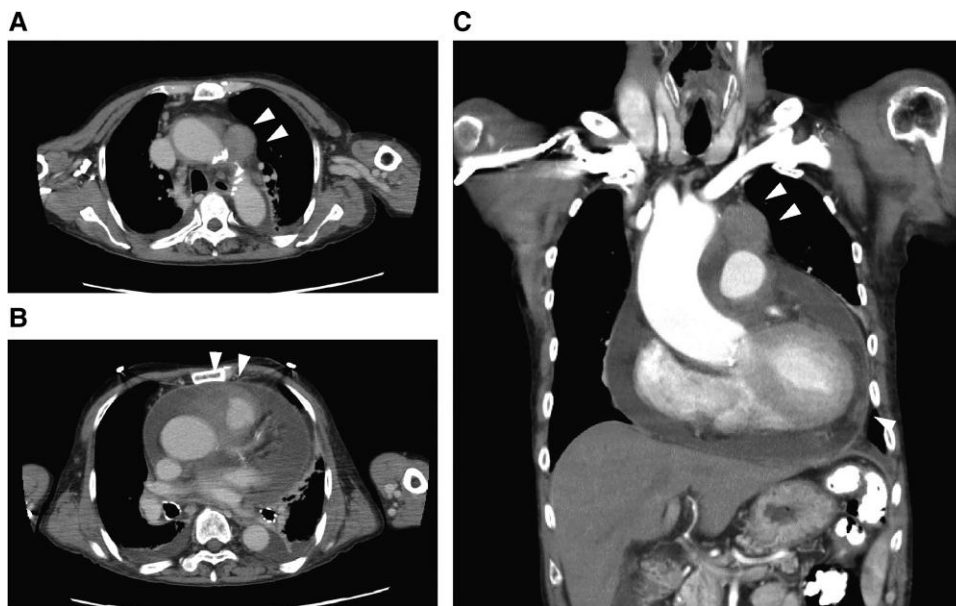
Contrast-enhanced computed tomography. The transverse (A, B) and coronal (C) sections. A large amount of pericardial effusion and thickening as well as a mass (arrow) were observed.
